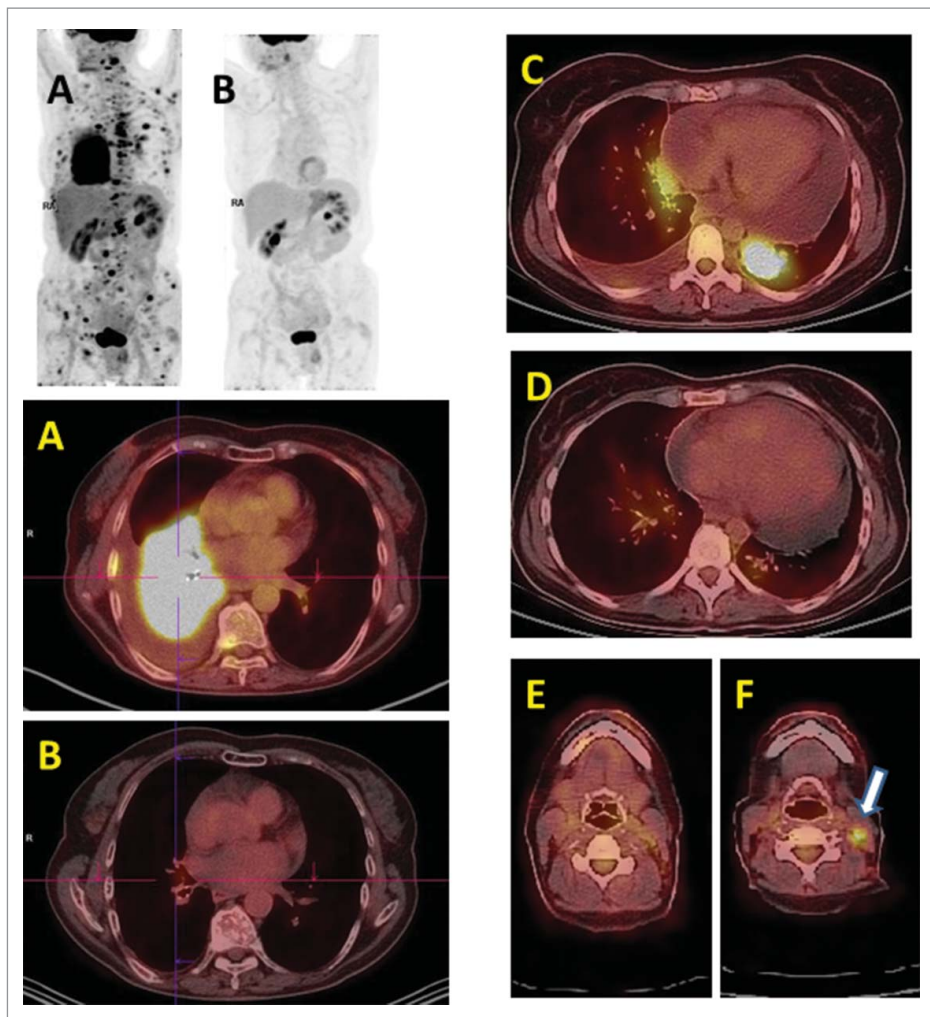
(A, B) Complete response to treatment in a woman aged 72, with initial PS 2; EGFR deletions. PET/CT scan with representative sections before treatment (A) and after treatment (B). C, D, E, F: Mixed response to treatment in a woman aged 41, EGFR deletions. At 6 months, comparison of PET/CT scans before treatment (C) and after treatment (D) reveals complete metabolic response on the site of the primary tumor. However, a new lesion (F) is visible in a previously uninvolved site on the neck (E). In accordance with the rules for assessment of metabolic response to treatment, this was classified as progression.
